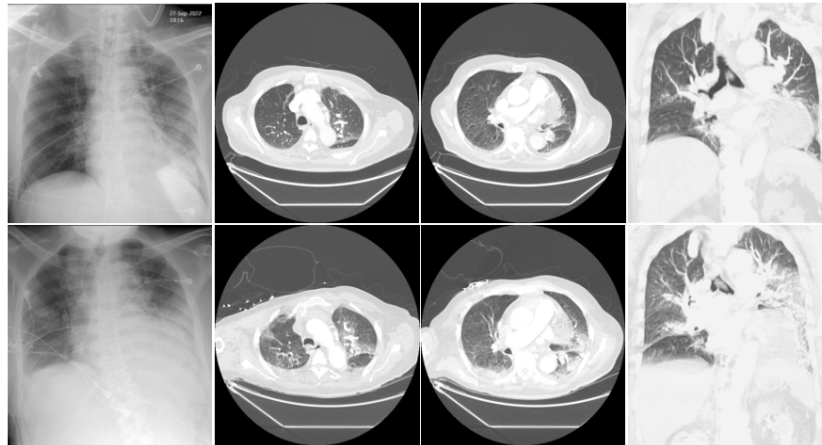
Chest X-ray and CT chest lung windows before (top row) and after (bottom row) thrombectomy.
